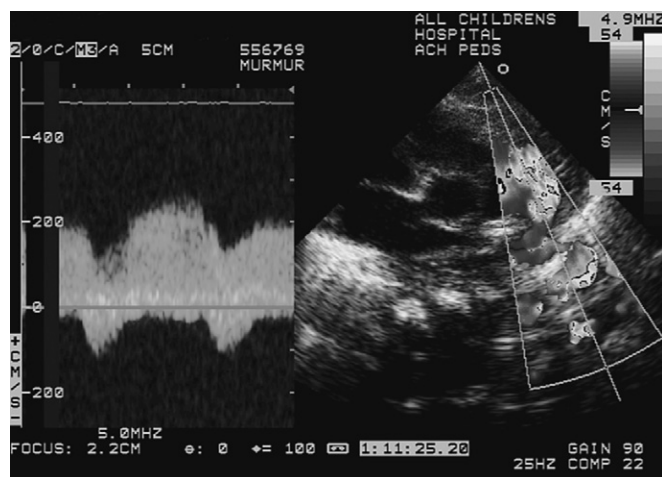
Patent ductus arteriosus in a neonate with a heart murmur. *Left*, Left-to-right shunt velocity is measured by continuous-wave Doppler as a peak of 2.3 m/s. *Right*, Left-to-right shunt into the pulmonary artery is seen by color Doppler.
